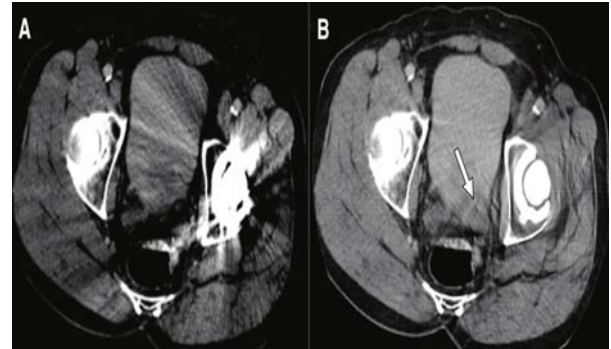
CT scan images of an organ with (image A) and without the presence of a metal artifact (image B).
